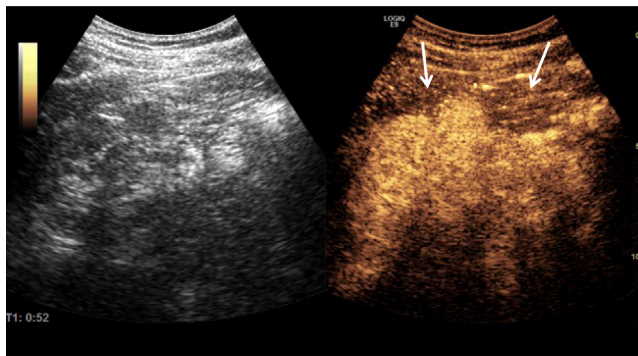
(Left) in patient CEUS-008, left kidney has poor corticomedullary differentiation on conventional grayscale ultrasound. (Right) contrast-enhanced ultrasound image taken at same time and in same plane as grayscale image. Arrows highlight large, wedge-shaped, hypoechoic areas not visualized on grayscale image on left.
